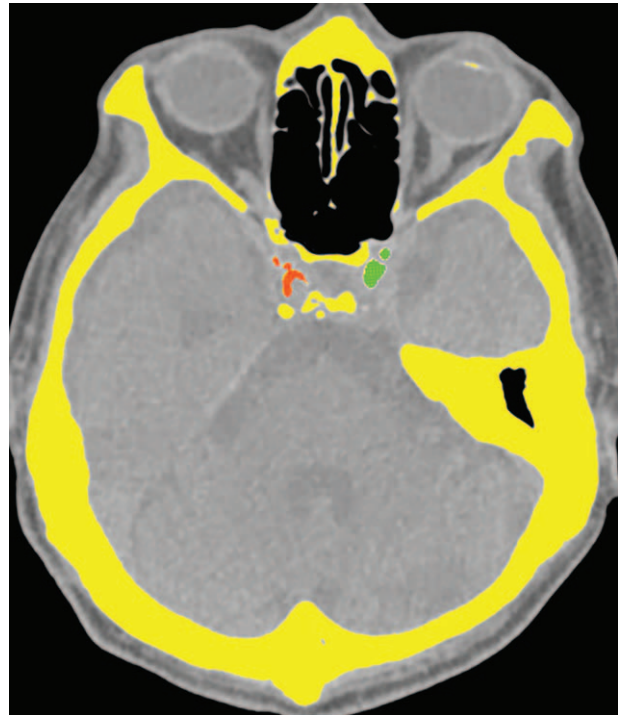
Agatston calcium scoring for a 59-year-old man. On the axial noncontrast CT images, the software automatically highlighted densities greater than 130 Hounsfield units in 2 continuous pixels in yellow color. A neuroradiologist selected the regions of interest in the bilateral intracranial internal carotid arteries (labeled in red on the right and in green on the left) for calcium scoring (total ICA Agatston calcium score, 76.8).
